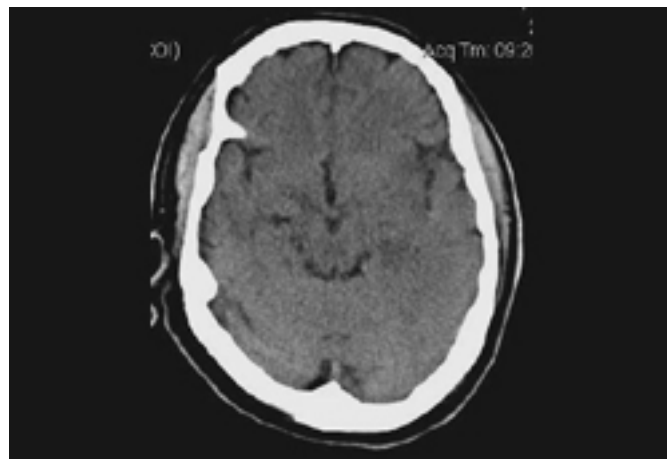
Noncontrast head CT of a patient with HSV encephalitis: shows subtle hypodensities involving the left insular region. Some blurring of gray-white margins and sulcal effacement over the left temporal region is discernible
